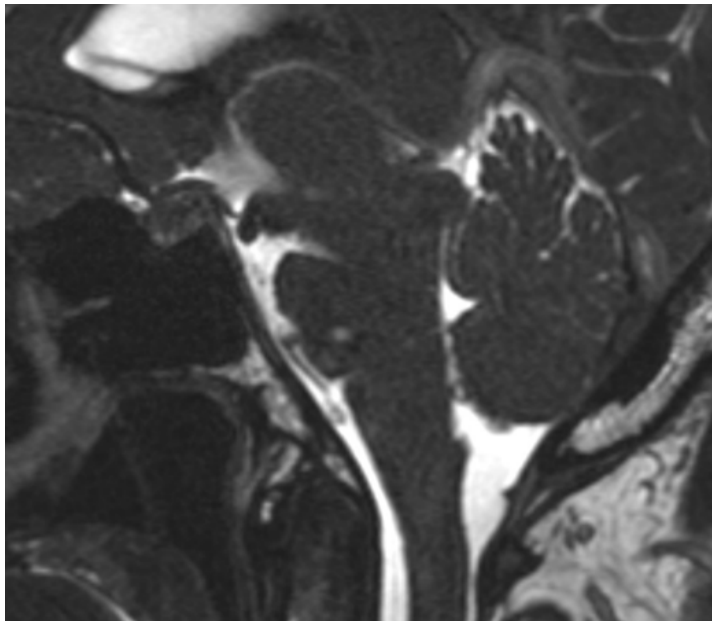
Midline sagittal steady-state MR image of the brain shows brain sagging, with descent of the optic chiasm, floor of the third ventricle and mammillary bodies, with reduction of the cisterns of the posterior fossa.
